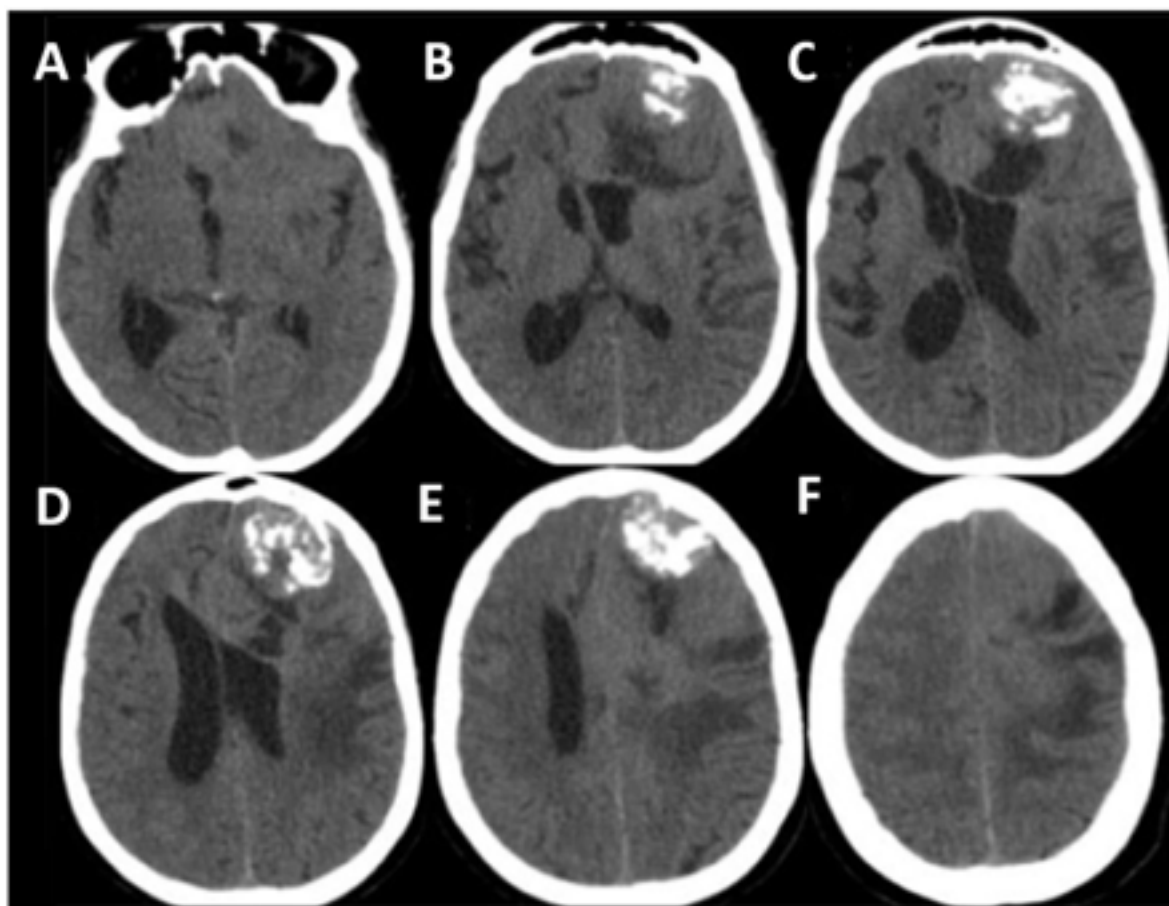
A-F. CT scan of the skull in axial sections, showing an extra-axial lesion on the left front with calcifications, possibly corresponding to a meningioma, measuring approximately 3.9 cm and with perilesional vasogenic edema.
